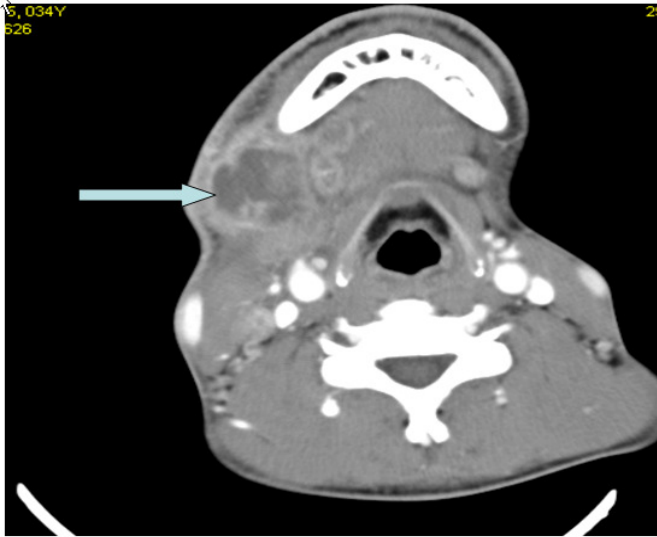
Axial contrast enhanced CT scan shows a 3 cm diameter mass next to submandibular gland suggesting a suppurative lymph node and very small lymph nodes.
